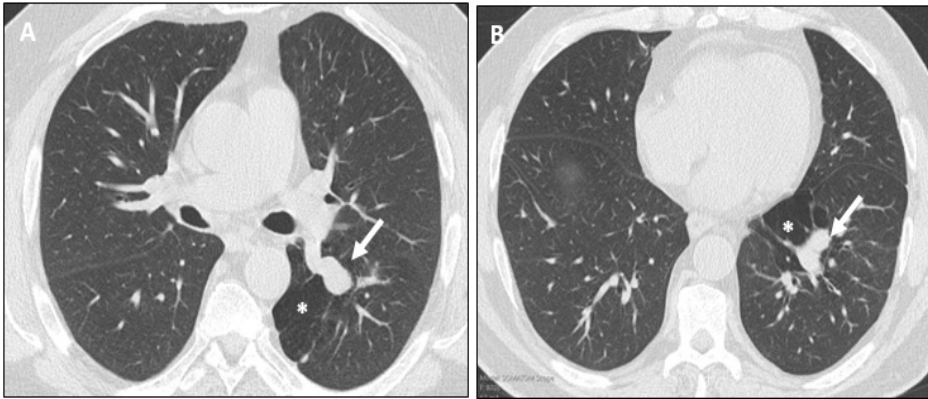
Chest CT axial images with branching tubular opacities (white arrows) in the superior segment (A) and medial basal segment (B) of the left lower lobe representing bronchoceles with focal oligoemic areas (*) of the adjacent lung parenchyma.
